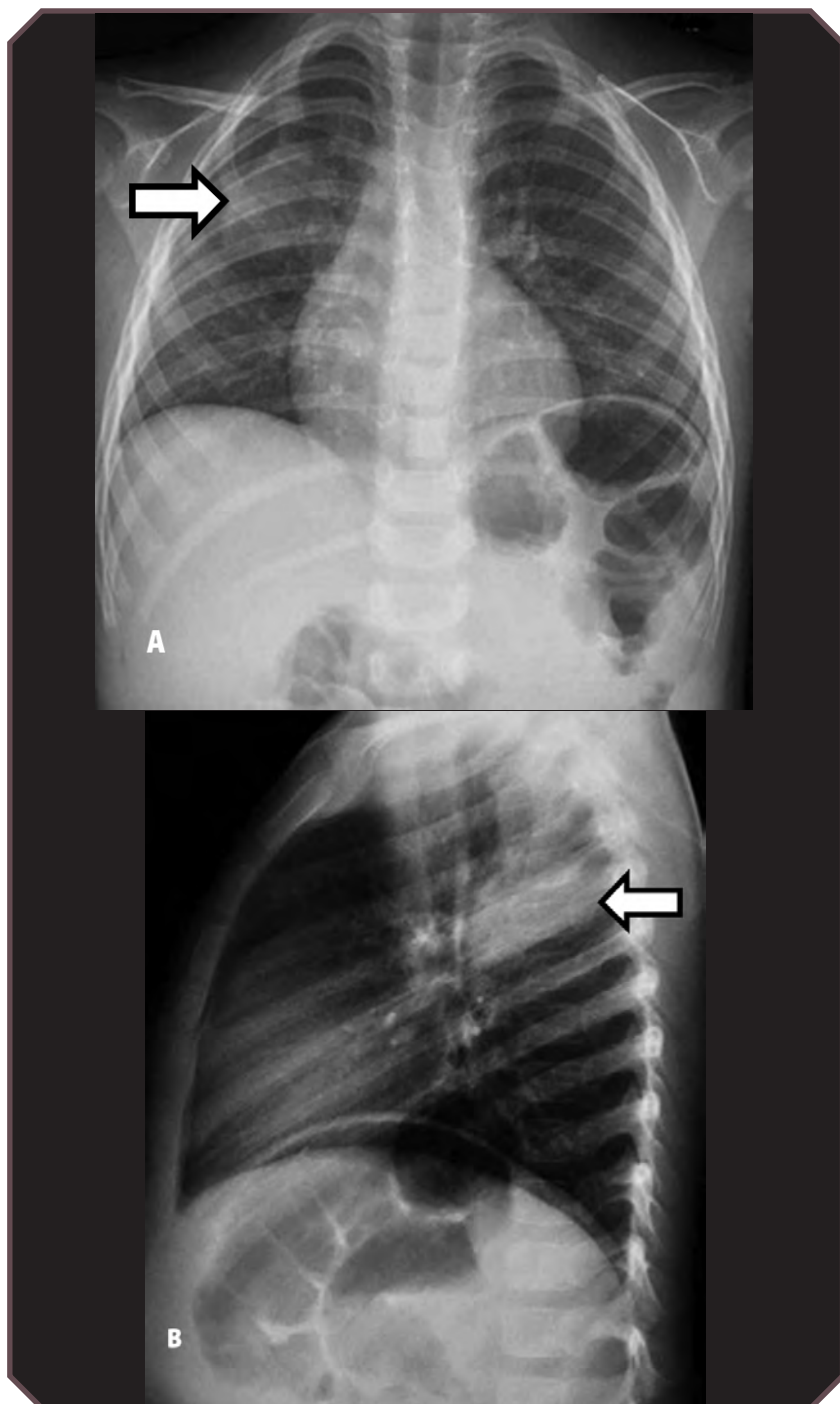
Right upper-lobe pneumonia in a 3-year-old girl. A. Frontal and B. lateral chest radiographs demonstrate focal consolidation in the right upper lobe (arrows).
